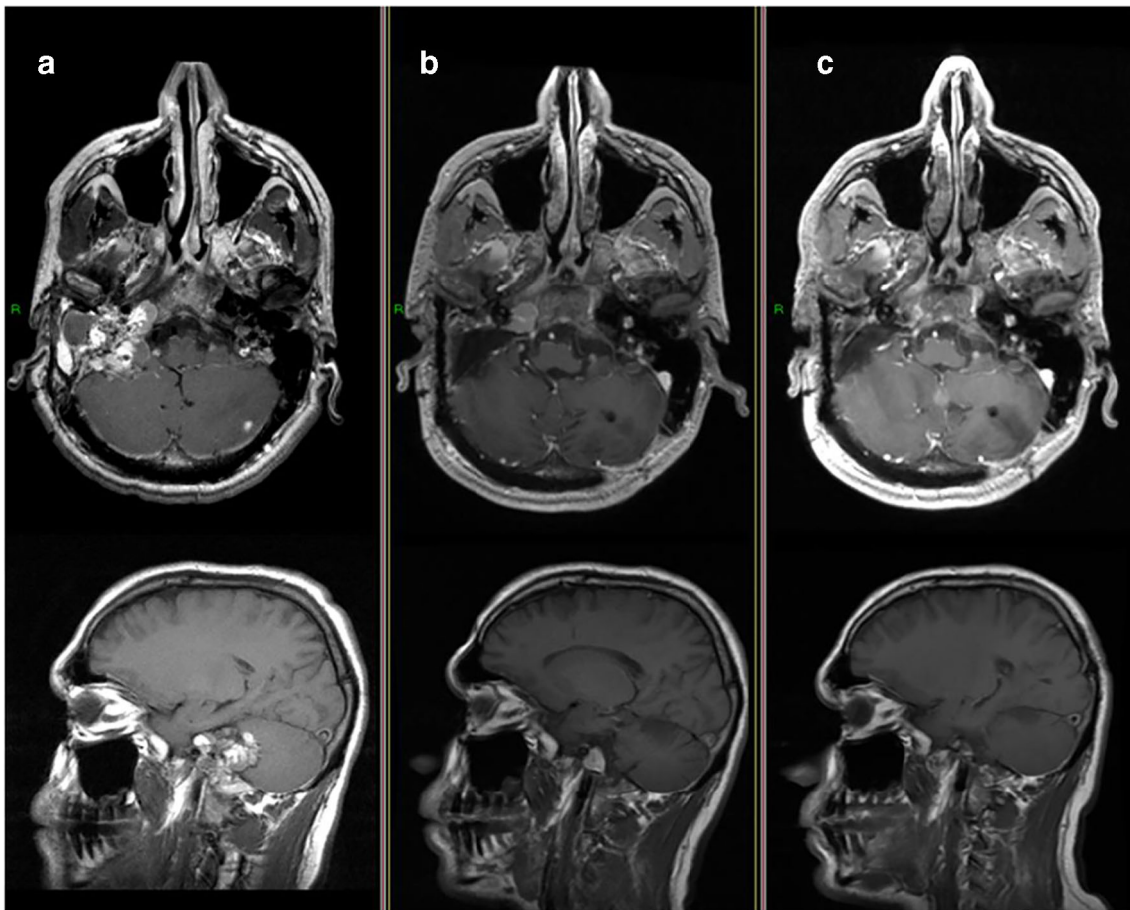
Longitudinal T1-weighted, with and without gadolinium enhanced MRI follow-up of a 31-year old female with a right-sided GJT. A. pre-LINAC SRS treatment. B. Tumor shrinkage is demonstrated
